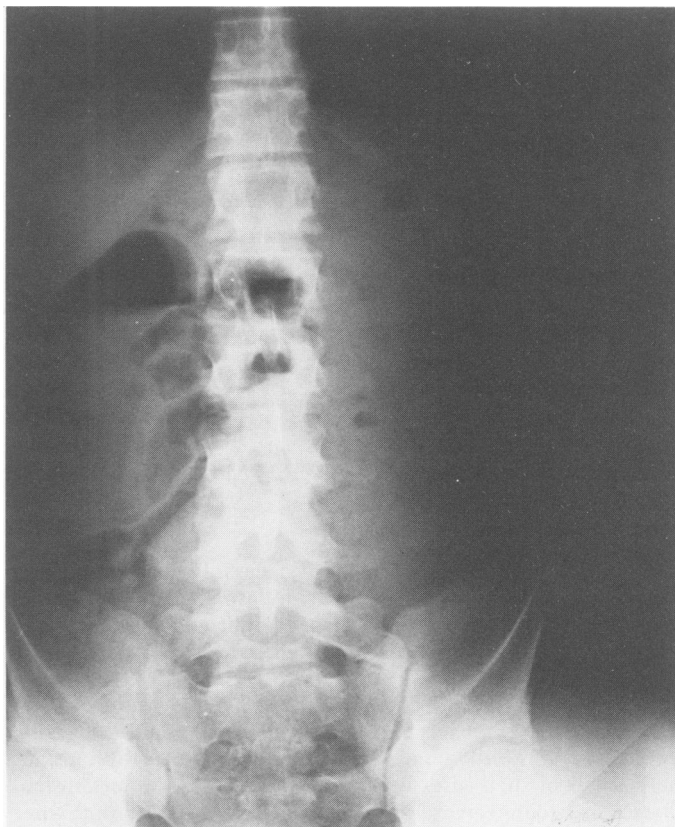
(P.W.) Upright roentgenogram of the abdomen taken on admission to hospital and showing multiple air-fluid levels.
